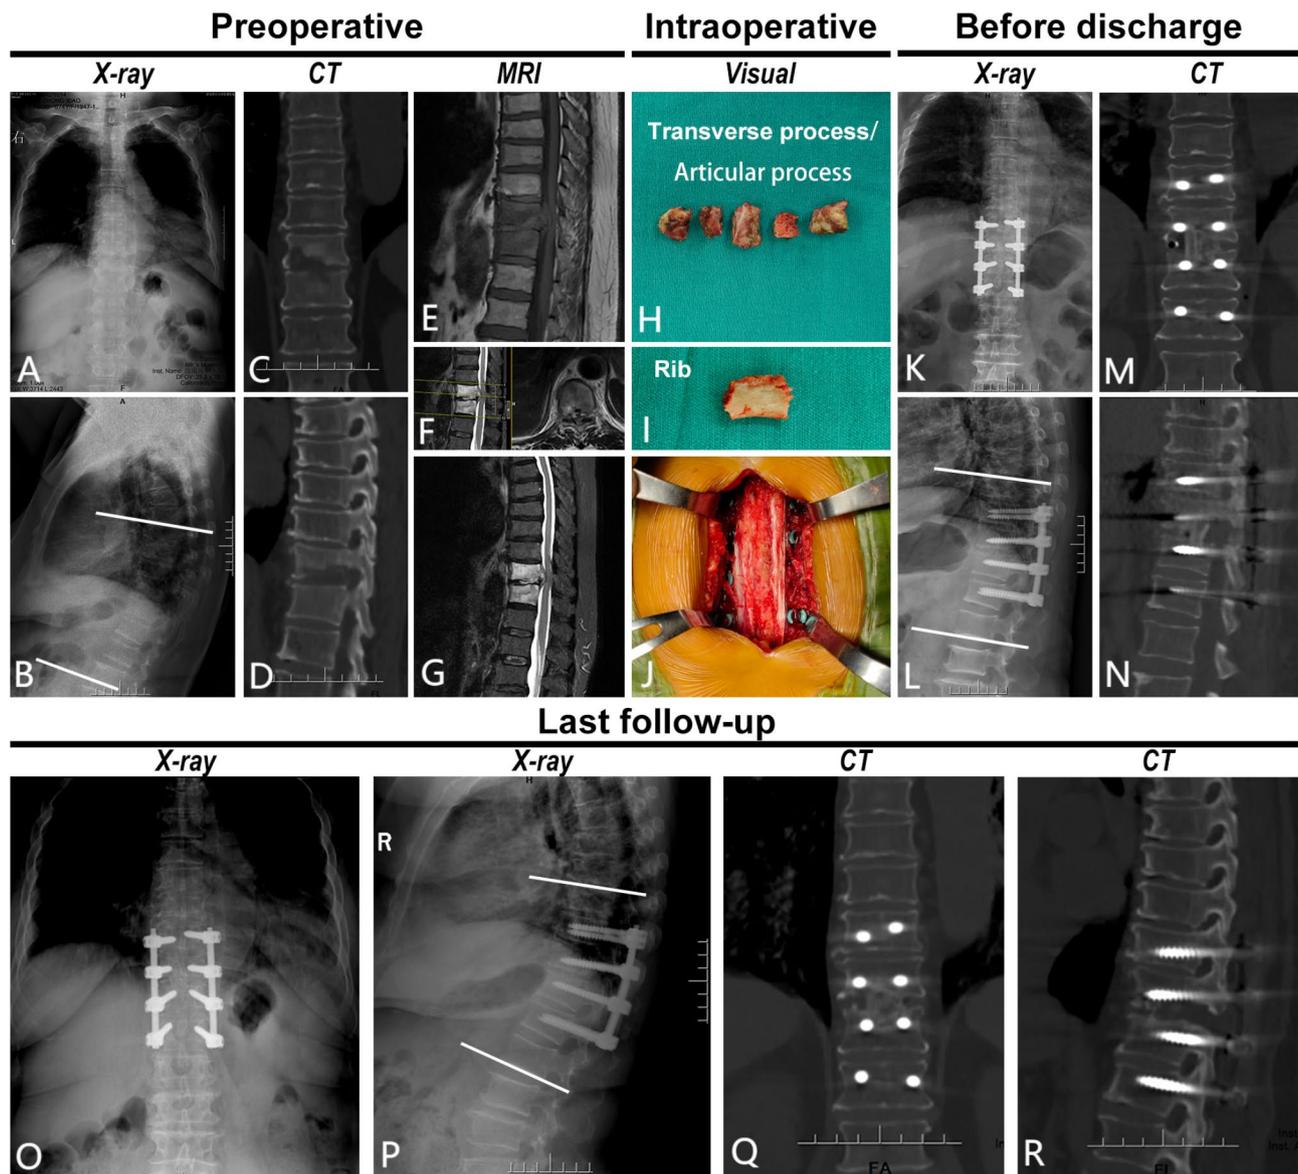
A 70-year-old female was diagnosed with thoracic suppurative spondylitis and incomplete paralysis. Neurological deficit was ASIA D. A–B preoperative X-ray showed that T₇–T₈ vertebral body destroyed. C–G preoperative CT and MRI showed T₇–T₈ vertebral body destruction with spinal canal abscess and spinal cord compression. H–J intraoperative image showed one-stage posterior debridement, autogenous bone grafting, and internal fixation via the multifidus and longissimus interspaces. K–N postoperative X-ray and CT before discharge showed well-positioned strutting bone grafting and instrumentation. O–R X-ray and CT presented a favorable alignment and satisfactory bone fusion at 13-month follow-up
